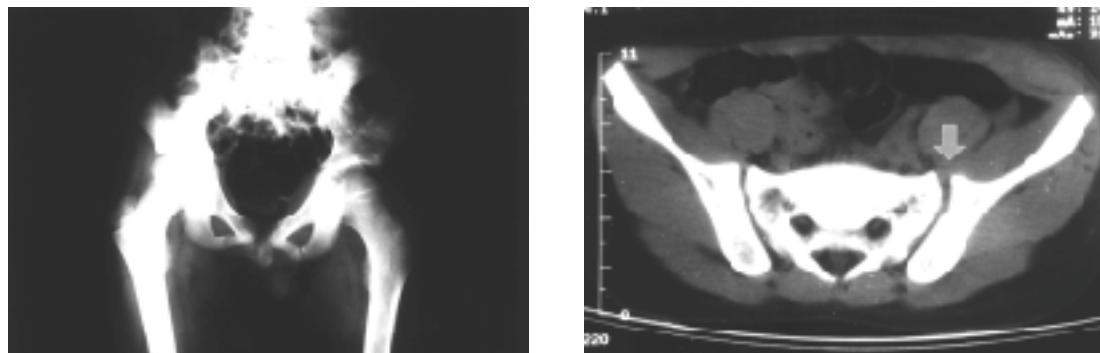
Pelvis anteroposterior radiograph shows left inferior ramus longitudinal fracture.
